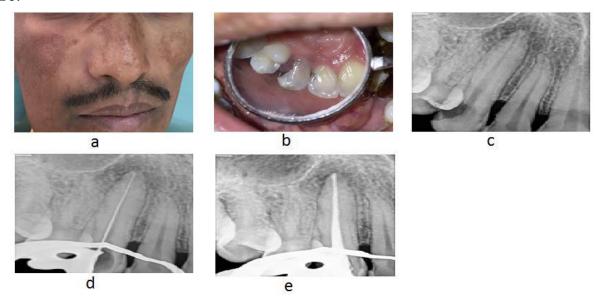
a-Extraoral examination; 3.b- intraoral carious tooth 13; 3.c- preoperative radiograph; 3.d- working length radiograph; 3.e-obturation radiograph.
